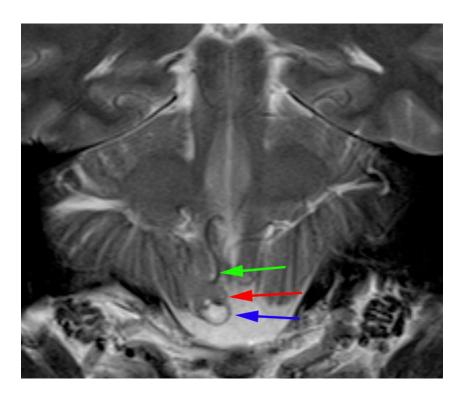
In the T2 coronal MRI
